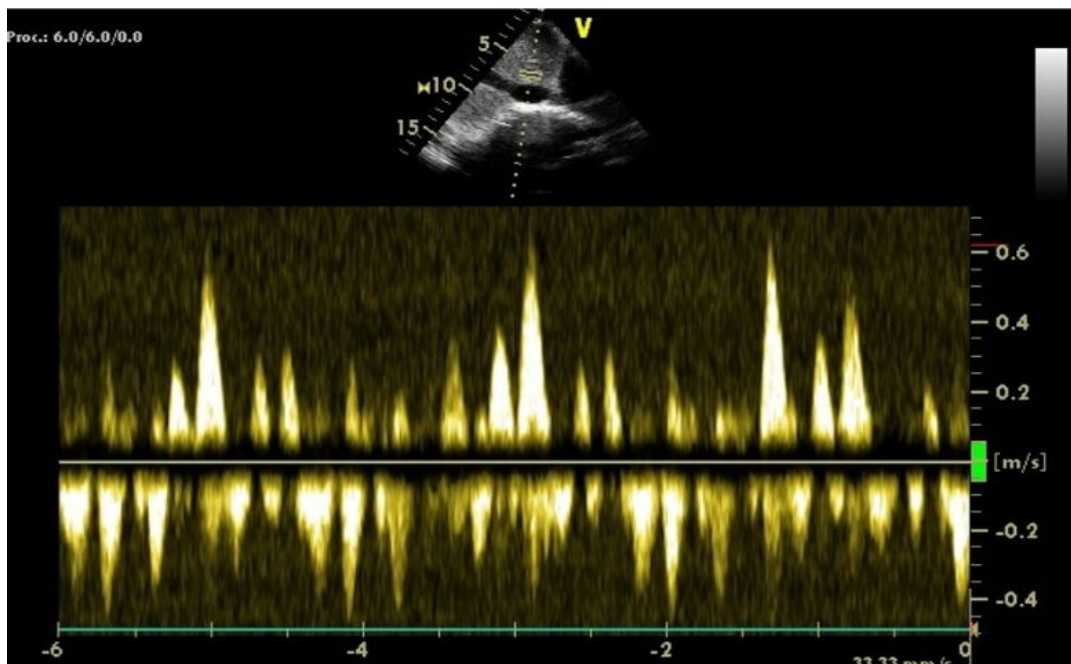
Figure legend 3: Pulse wave doppler flow at hepatic vein shows marked variation in velocities suggestive of interventricular dependence phenomena seen in constrictive pericarditis.
